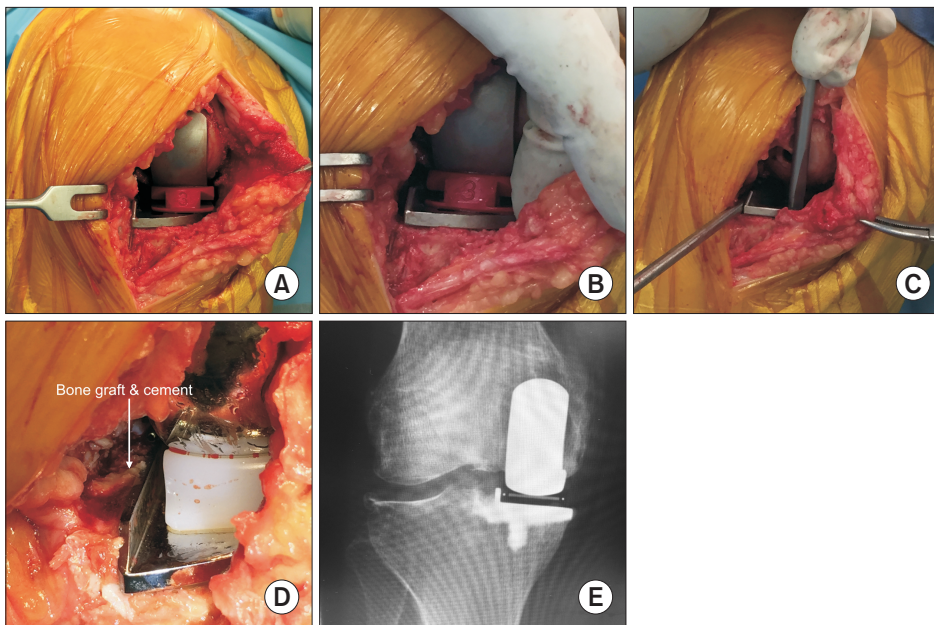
Intraoperative procedure. (A) Approximately 3-mm space is shown between the mobile bearing (MB) and the vertical wall of the tibial component (VW), showing the bearing separation. (B) The tibial template is shifted laterally to make a 1-mm space between the MB and the VW. (C) The intramedullary rod is inserted to maintain the distance between the vertical cutting surface (VC) and the VW. (D) Bone chips are inserted between the VC and the VW, followed by cement filling. (E) A postoperative radiograph showing the space between the VC and the VW filled with the cement.
